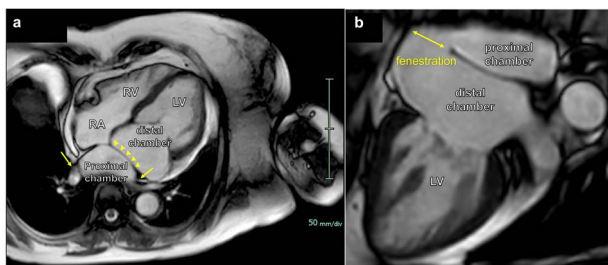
Cardiac magnetic resonance imaging after initial treatment. (a) All pulmonary veins opened into the proximal chamber of LA (arrows). The left atrium was divided into proximal and distal chambers by an abnormal septum (arrow heads). (b) The fenestration site was only detected in the median side of the left atrium. LV, left ventricle; RA, right atrium; RV, right ventricle.
